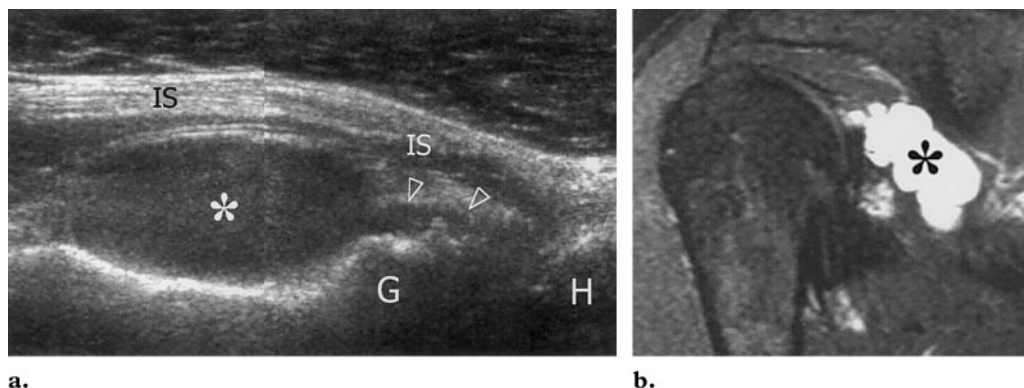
Suprascapular nerve entrapment at the spinoglenoid notch in a 54-year-old man. Longitudinal 12–5-MHz US image obtained over the posterior shoulder (a) and corresponding coronal fat-saturated GRE MR image (700/15/20°) (b) reveal an oval cystic lesion (*) located deep to the infraspinatus tendon (IS) and medial to the glenoid (G), a finding that is consistent with a ganglion cyst. Note the thin neck of the cyst (arrowheads in a) directed toward the GHJ. H = humeral head.
